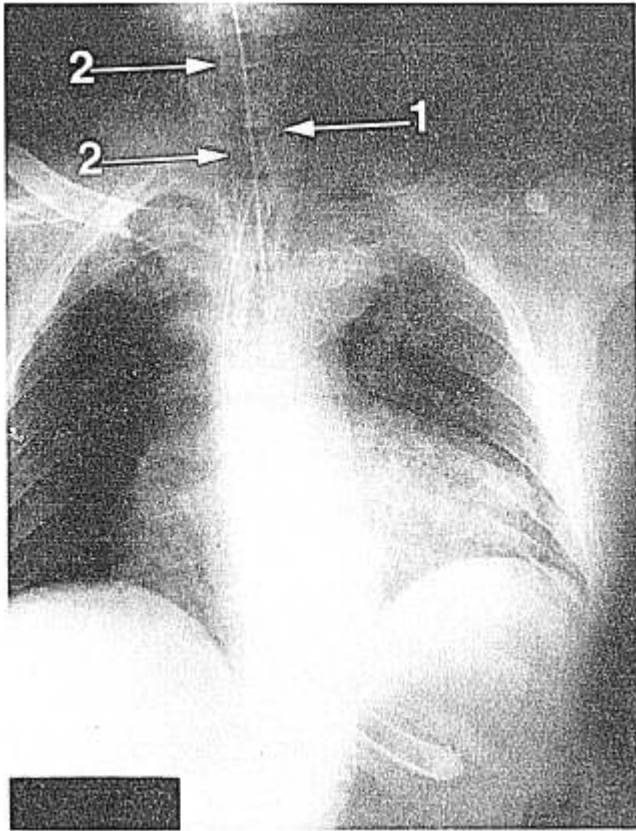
Chest roentgenogram revealing the esophageal obturator airway with the distal tip in the stomach below the diaphragm and the proximal tip to the left of the patient's larynx (arrow #1). An oral endotracheal tube is in position within the trachea (arrow #2).
